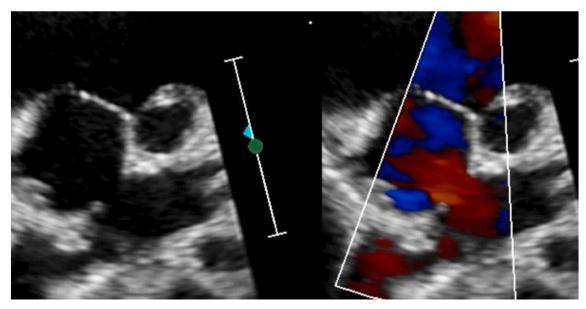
Parasternal short axis view - showing retro-aortic rim in a secundum atrial septal defect.
